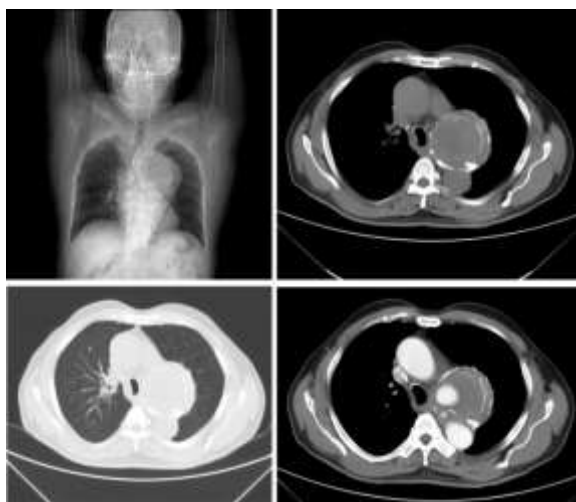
CT- Aortogram showing dissecting aortic aneurysm with saber sheath trachea
